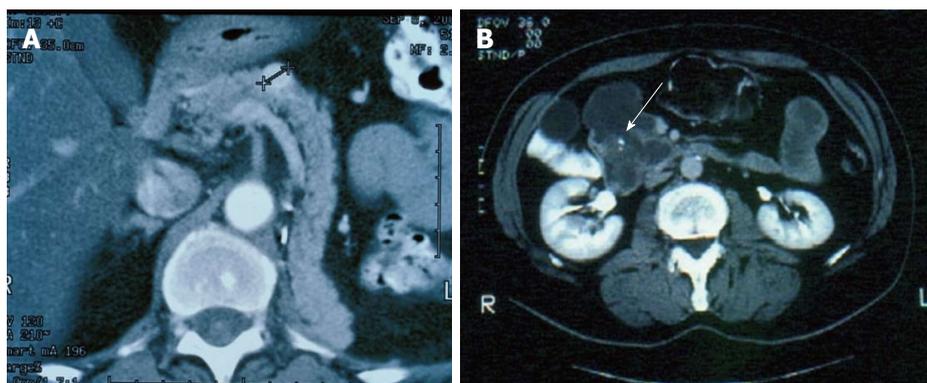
Computed tomography scan of the abdomen. A: Computed tomography (CT) scan of the abdomen showing a contrast-enhanced pancreatic metastasis from a renal cell carcinoma; B: CT scan of the abdomen showing a hypodense metastatic lesion of the pancreatic head from a colon carcinoma.
